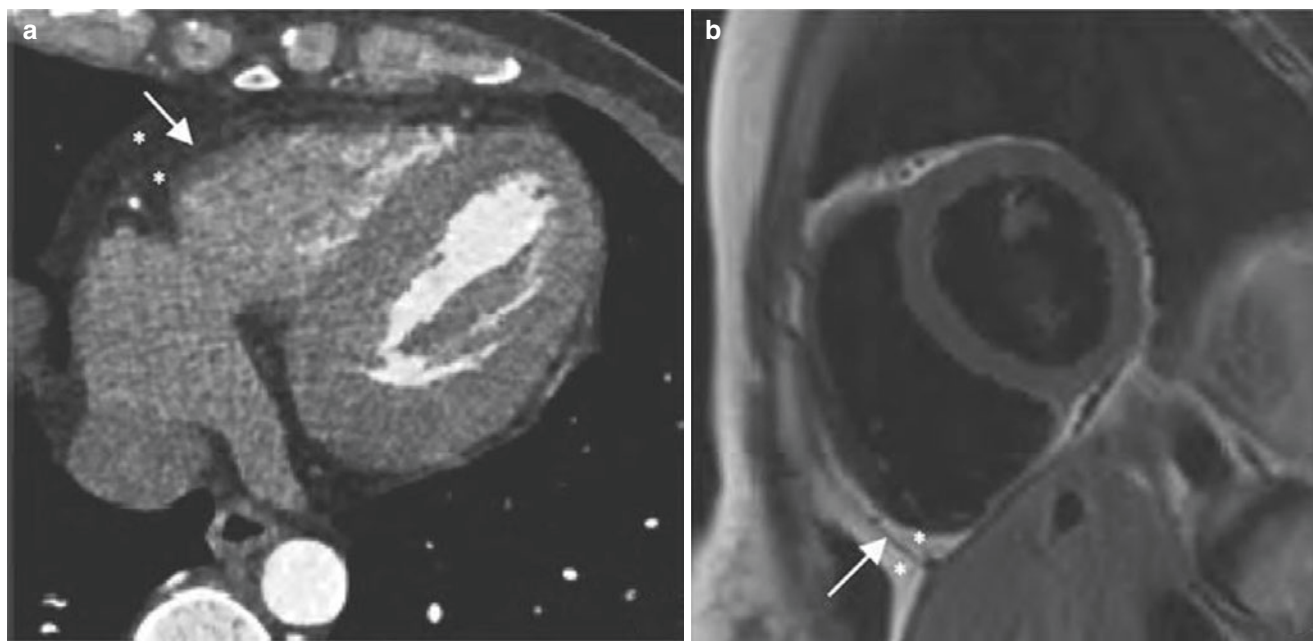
Normal pericardium. (a, b) CT and MRI showed that the normal pericardium (arrow) and adjacent fat (*) in the free wall of right ventricle were manifested as sandwich-like changes, and the thickness of normal pericardium was less than 3 mm
